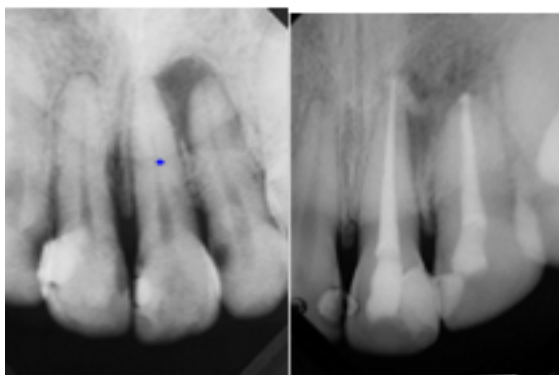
A pre-operative and post-operative radiograph of the patient.
